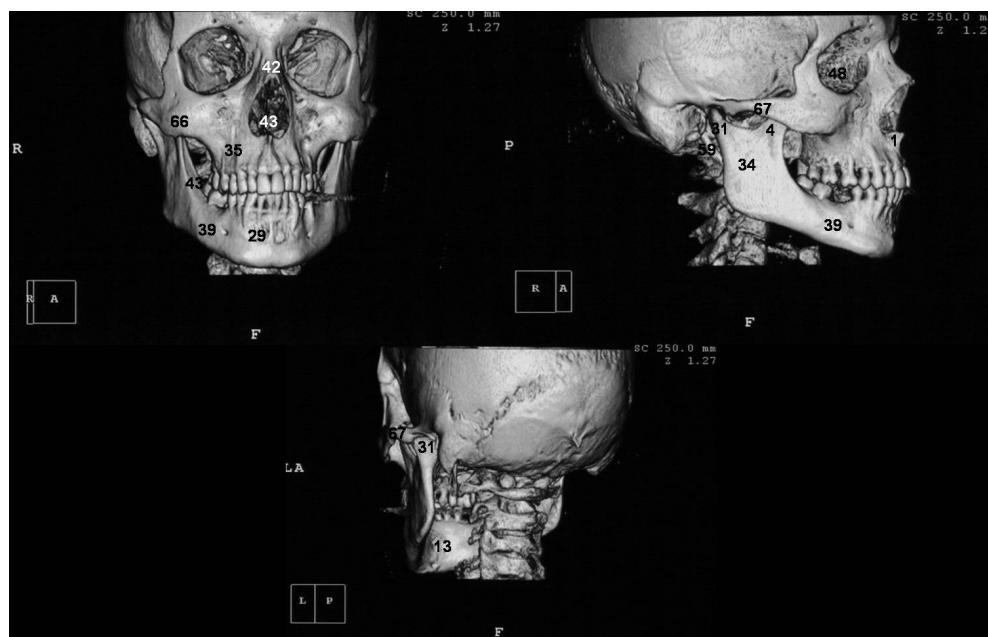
3D CT anatomy of the facial skeleton
